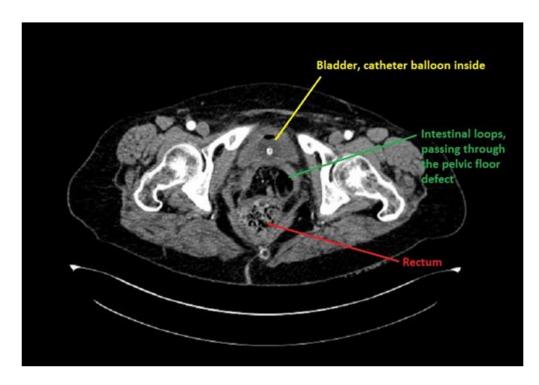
An axial image from the CT scan of abdomen
